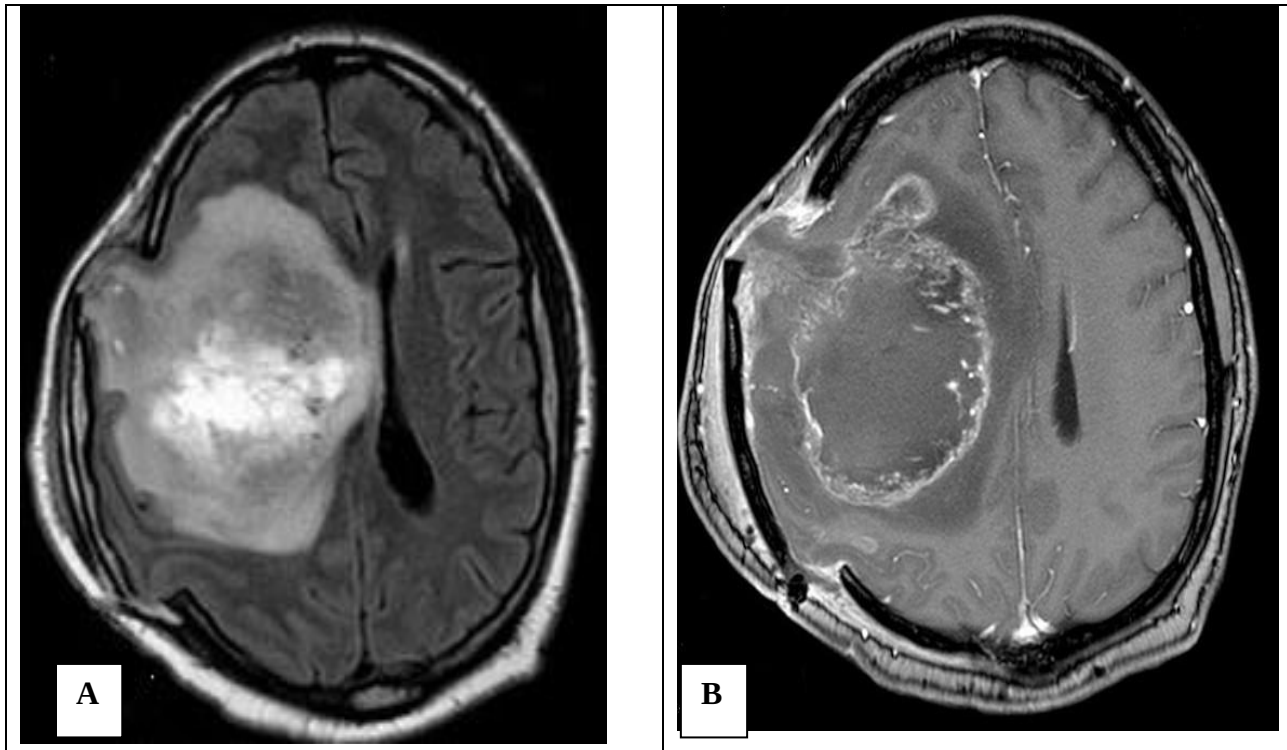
Axial MR images (A. FLAIR; B. T1 gadolinium-weighted) performed at one week after the second surgery highlighted a huge heterogeneous infiltrating mass that filled frontal, temporal and parietal lobes, with extensive peripheral edema and midline shift, all these features being indicative of rapid tumor progression.
